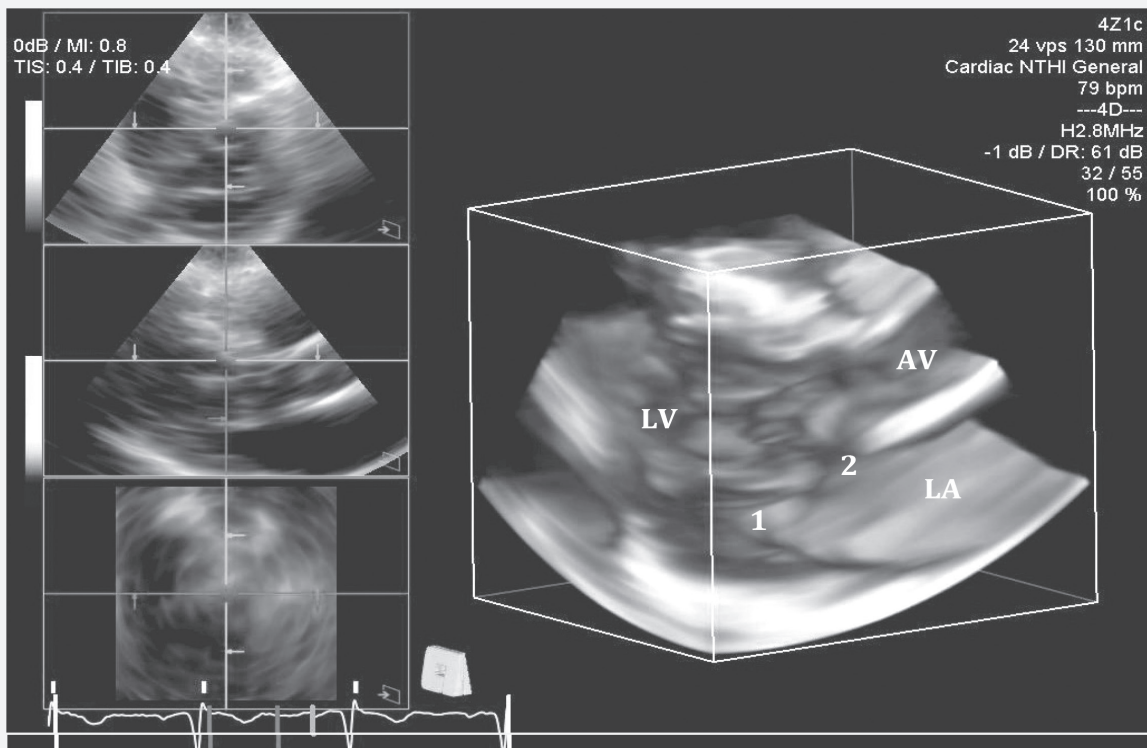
Transthoracic 3D echocardiography simultaneous imaging of mitral valve from multiple planes. Freezing the 3D image during diastole reveals the presence of two distinct mitral valve orifices (1 and 2). Abbreviations: 3D, three-dimensional, AV, aortic valve; LA, left atrium, LV, left ventricle.
